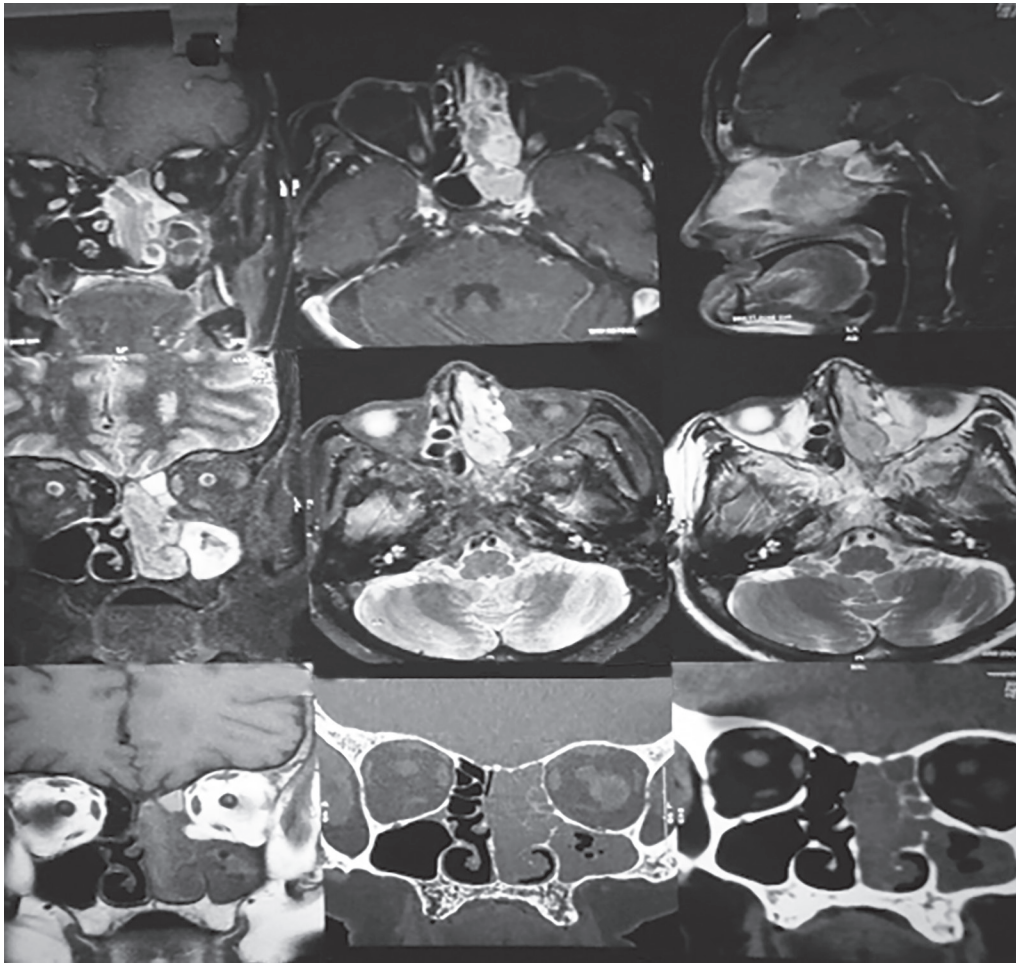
MRI and CT scan of a patient with sinonasal malignant melanoma. On imaging, the tumor appeared to be filling the entire nasal cavity on the left side with retained secretions in paranasal sinuses. During surgery, the tumor had a small narrow attachment at posterior end of septum which could be resected endoscopically easily with adequate margins
